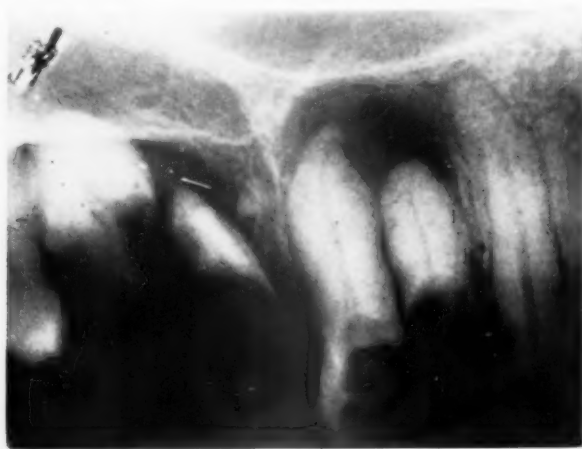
Tuberculous periapical involvement of several teeth.
